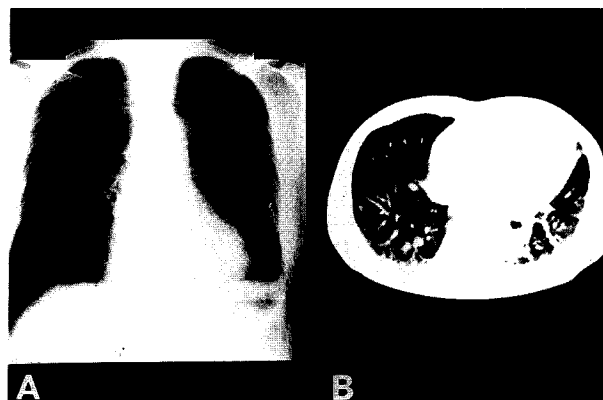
Absence of multiple lung metastases on chest roentgenogram (A) and CT (B) examination after OK-432 treatment.
